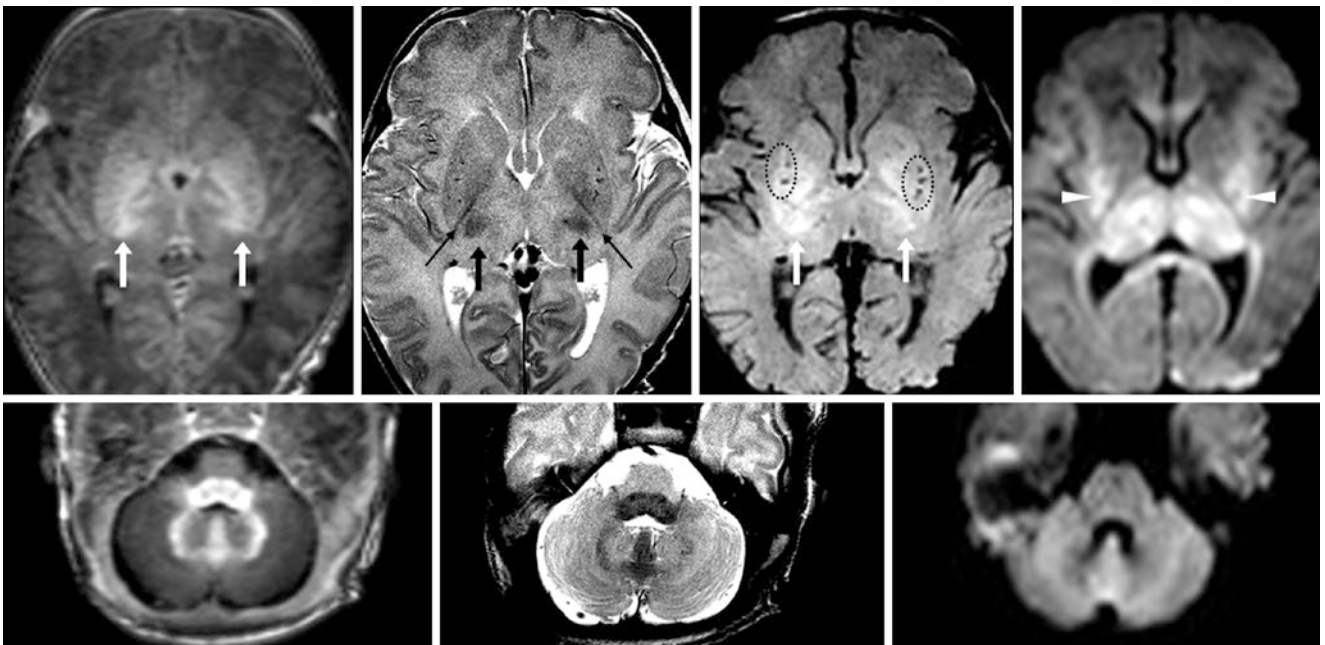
Comparison case of HII. A 4-day-old term neonate with hypoxia and a seizure underwent a 3T MRI. The LN and VLT (*arrows*) were uniformly bright on GE T1WI (*top left*), with mild edema on SE T2WI (*top, left middle*). On SWI (*top, right middle*) the LN and VLT were bright due to “T1 shine-through,” with punctate hemorrhages
